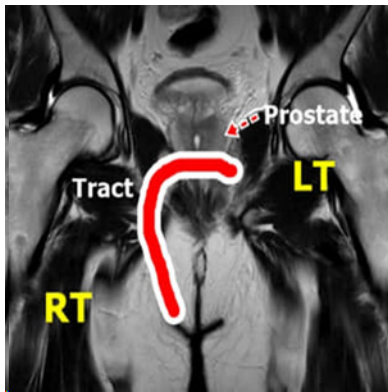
MRI T2 coronal oblique image: the red line shows the course of the sinus tract.
